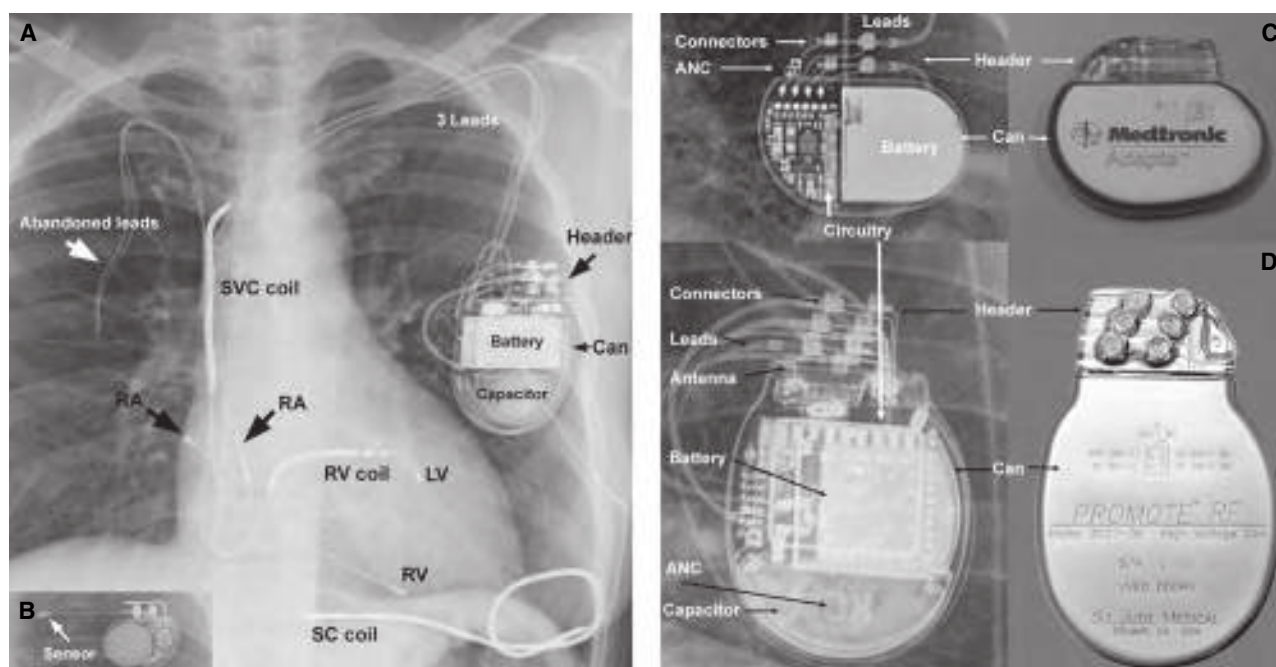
Assessing the ICD. A. Chest radiograph of a patient with a biventricular ICD. Note the right atrium (RA), right ventricle (RV), and left ventricle (LV) leads connected to the header. The RV lead has a combination of RV pace/sense lead, RV coil, and superior vena cava (SVC) coil. The subcutaneous (SC) coil is connected to the SVC port. Another set of RA and RV abandoned leads can be seen from a previous device implantation. B. The Transoma Medical implantable loop recorder. Note the flexible sensor (antenna) with no transvenous leads. C. The Medtronic Adapta pacemaker. D. The St. Jude Medical Promote RE ICD. (Photos used with permission from reference 39.)
